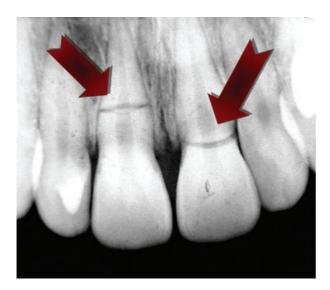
Initial radiography showing a mid-root fracture on the right central incisor and a cervical root fracture on the left central incisor.
